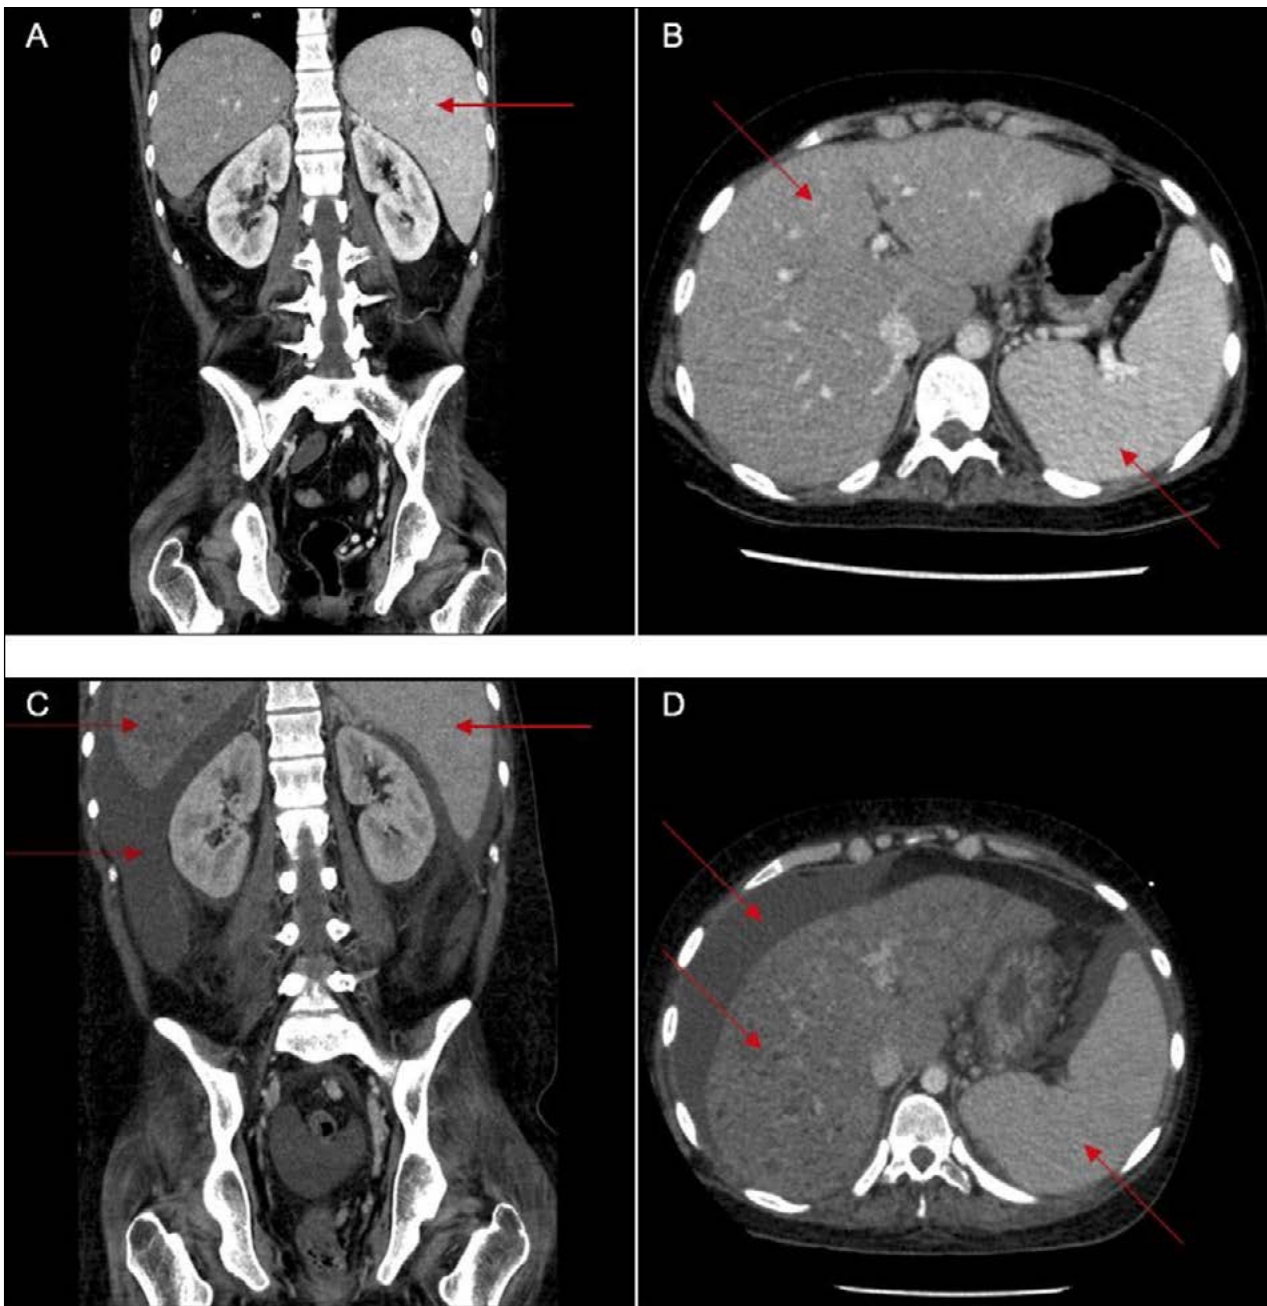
CT scan of the abdomen. A) Coronal scan showing normal intraabdominal conditions except for an enlarged spleen measuring 18 cm in craniocaudal length (arrow); B) Transverse scan showing normal liver and spleen tissues (arrows); C) Coronal scan showing multiple small hypodense lesions in the liver, ascites, and consistent splenomegaly (arrows); D) Transverse scan showing normal spleen tissue, but multiple small lesions in the liver tissue and ascites (arrows).
